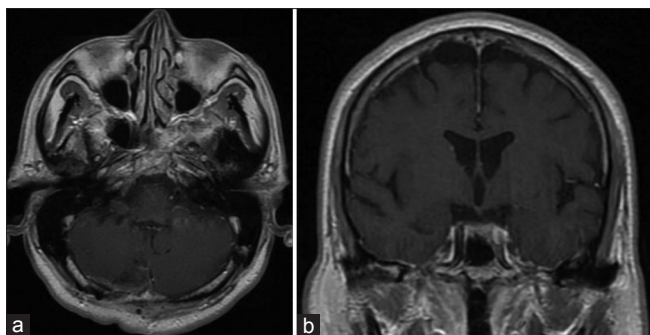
Contrast-enhanced T1-weighted MRI performed 1 month after the patient's operation. There is no evidence of the cystic lesions seen in Figure 2. There is resolution of the patient's obstructive hydrocephalus (b)
